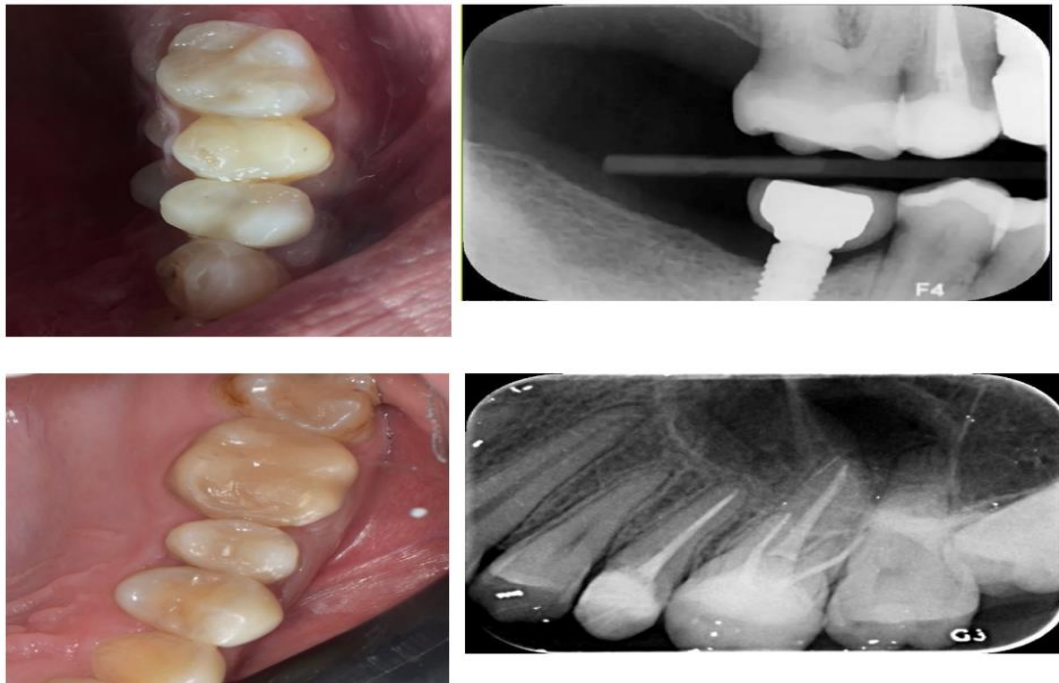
Clinical and radiographic follow-up after one year in case 1 and 2
